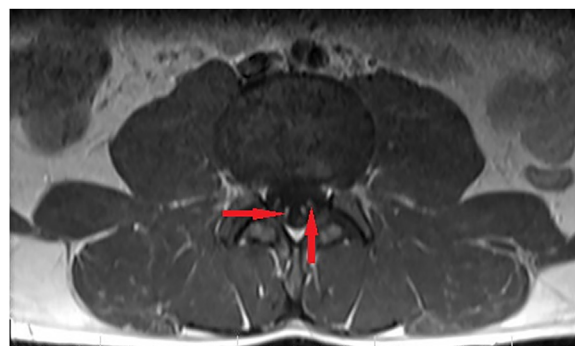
T1-weighted axial MRI with contrast view of the lumbosacral region in which root enhancements are pointed with arrows.
